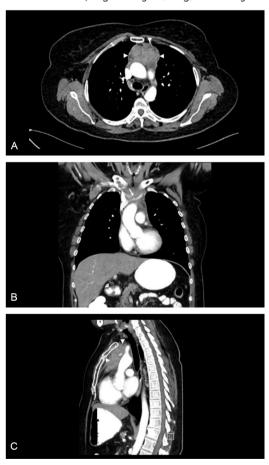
A) Axial image, B) coronal image, C) sagittal image. In contrast-enhanced thorax CT, a heterogeneous contrasting lobulated contoured mass filling the anterior mediastinum (white arrow) causes compression in the left subclavian vein, narrowing the lumen and surrounding it
